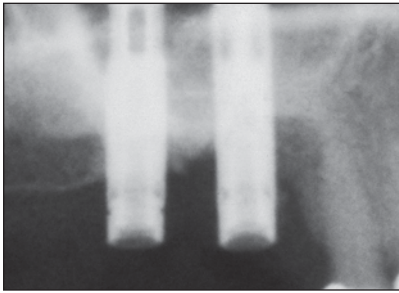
(left) Radiograph indicating chronically progressive peri-implant bone resorption.
